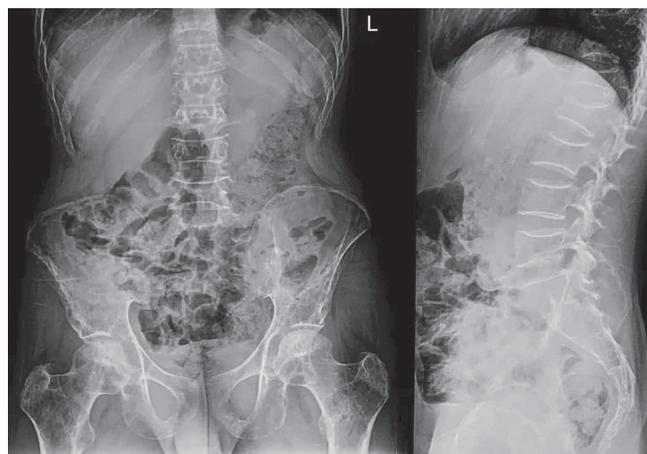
Anteroposterior (AP) and lateral X-ray of spine shows rarefaction of bones with collapse of multiple dorsal and lumbar vertebrae
